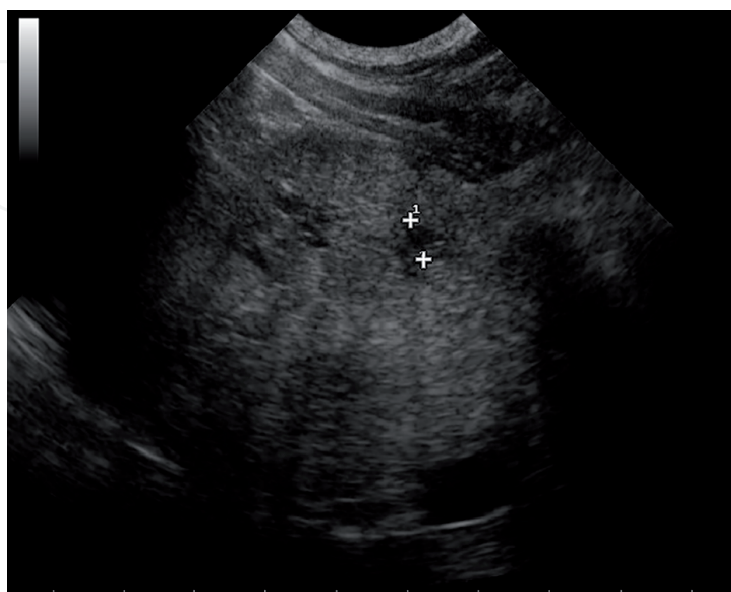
Sonography (B-mode) of a prostate gland with BPH and intraprostatic cysts. A small cyst is visible (white crosses). Cysts up to 3 cm in diameter can regress with anti-androgen therapy. Cysts filled with urine have a higher recidive rate, also after puncture.
